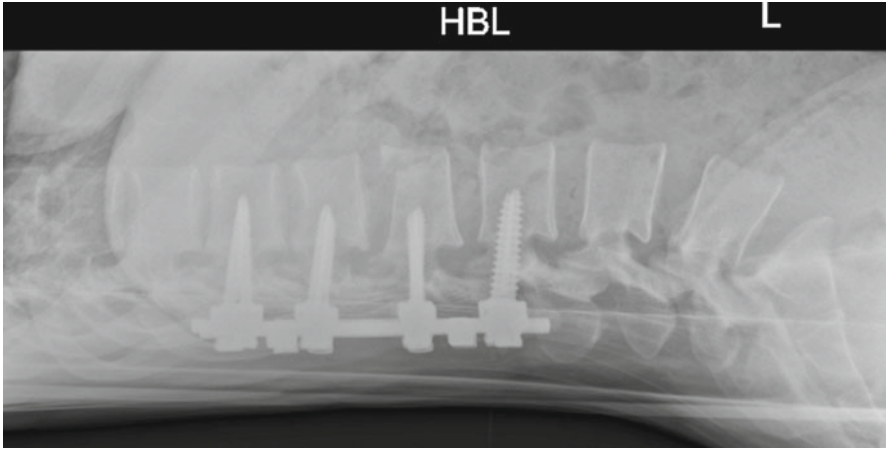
Lateral and anteroposterior radiographs demonstrating the use of pedicle screws for posterior instrumented fusion (Courtesy of Shibu P. Krishnan, London, UK)
